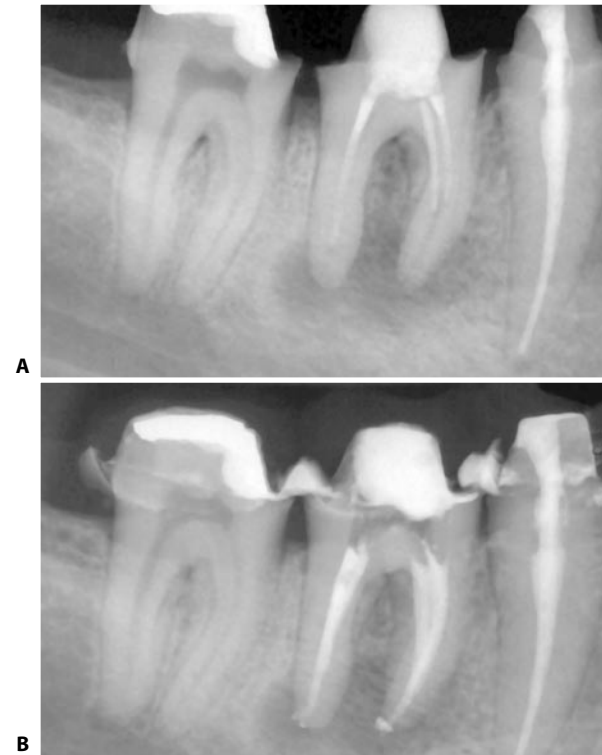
Retreatment of lower first molar. A. Preoperative radiograph: one notes a modest apical remodelling due to the lesion. B. Postoperative radiograph: one notes a good apical control of the obturation.
